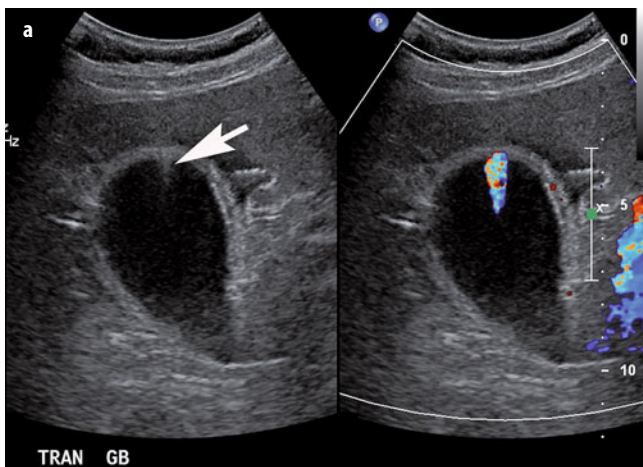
a, b. Adenomyomatosis. a Ultrasound (US) shows ring-down artifact (*arrow*) emanating from a mildly thickened gallbladder wall, with twinkle color artifact on color Doppler. b Fat-saturated T2-weighted magnetic resonance imaging (MRI) shows two bright foci (*arrow*) in the wall of the gallbladder fundus that represent Rokitansky-Aschoff sinuses. Gallstones are also present
